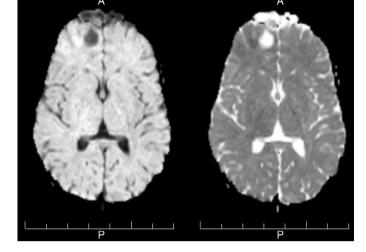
MRI of the brain showing a subdural frontal empyema.
